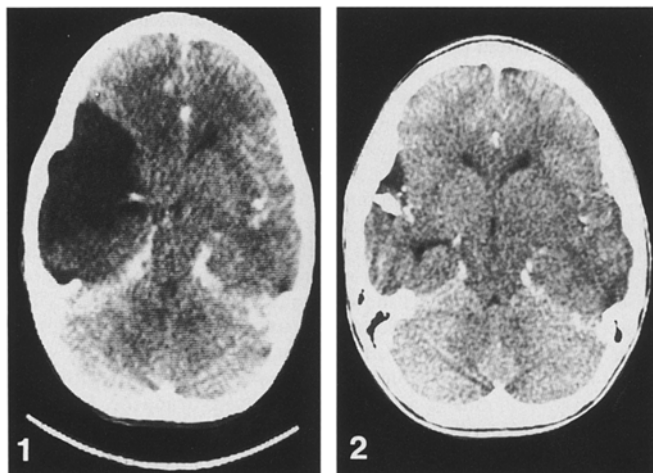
Preoperative cerebral CT scan of case 2 showing a right temporal arachnoid cyst with compression of the frontal horn of the right ventricle
